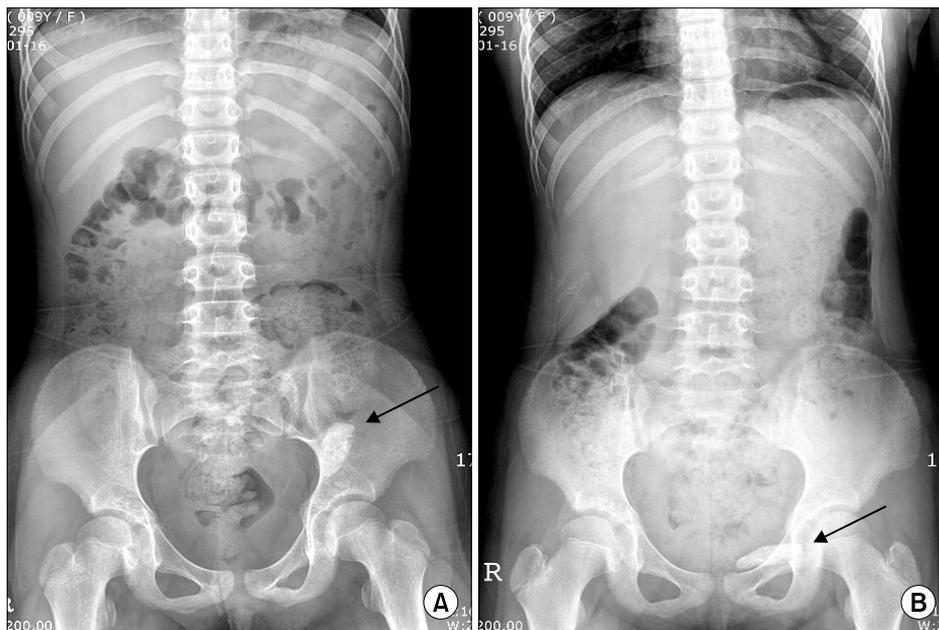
A plain X-ray film of the abdomen showed a calcified mass on the left side of the pelvic cavity (A), and a film obtained in a different view showed migration of the mass to a lower position (B).
